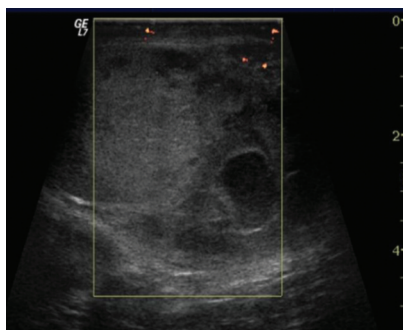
Ultrasound image showing left testicle rupture, with tunica albuginea discontinuity. No intratesticular vascularization was observed.
